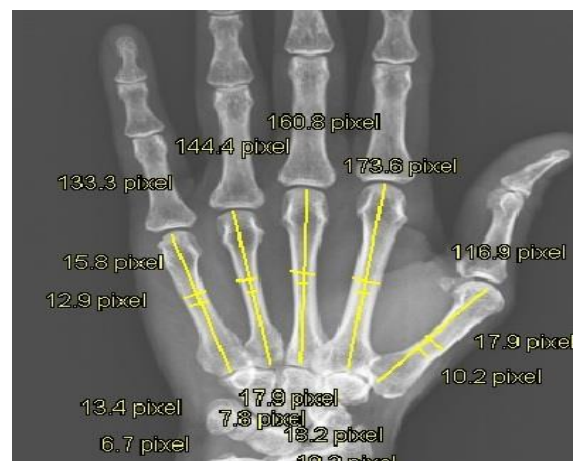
shows the metacarpal geometry variables that were measured from the digital hand radiograph in a normal Indian woman.
